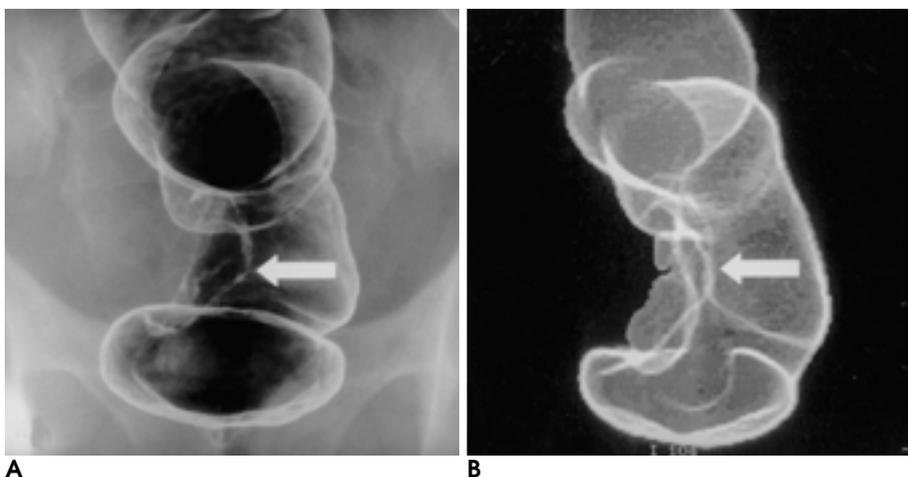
Barium enema (A) and CT colonogram (B) show irregular polypoid filling defect (arrow) in right lateral wall of rectum.
